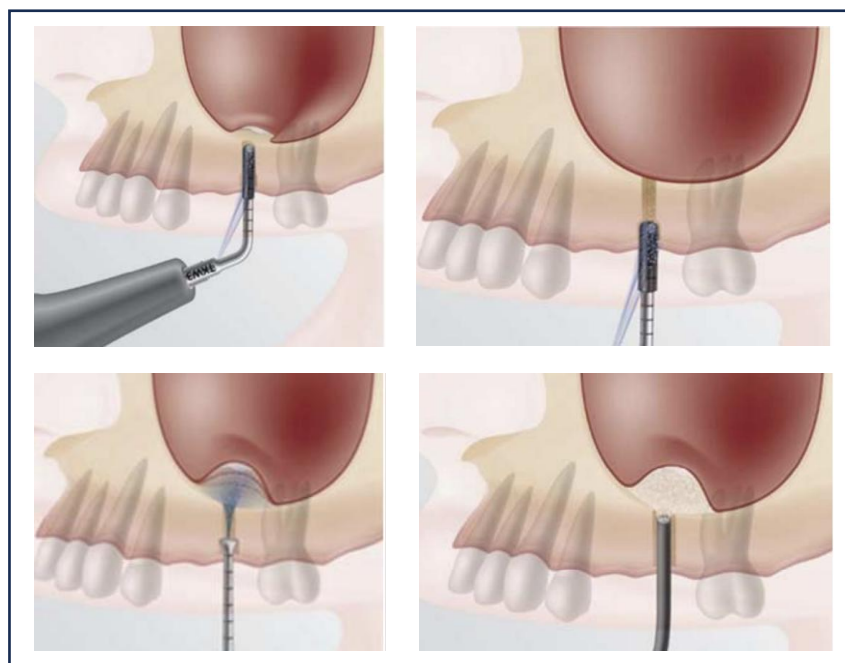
steps of trans-crestal hydrodynamic ultrasonic cavitation sinus lift.
